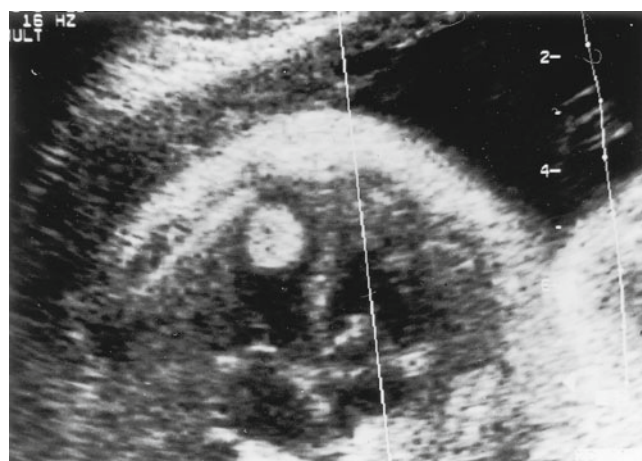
Cardiac rhabdomyoma. Sonogram of a fetus at 32 weeks gestation demonstrating a round echogenic mass bulging into the cavity of the left ventricle. Several additional tumors were visible in other views. The baby proved to have tuberous sclerosis but survived (Courtesy of Val Catanzarite, M.D., Perinatology, Sharp Memorial Hospital, San Diego; Reprinted from Isaacs [4]. © WB Saunders 1997)
